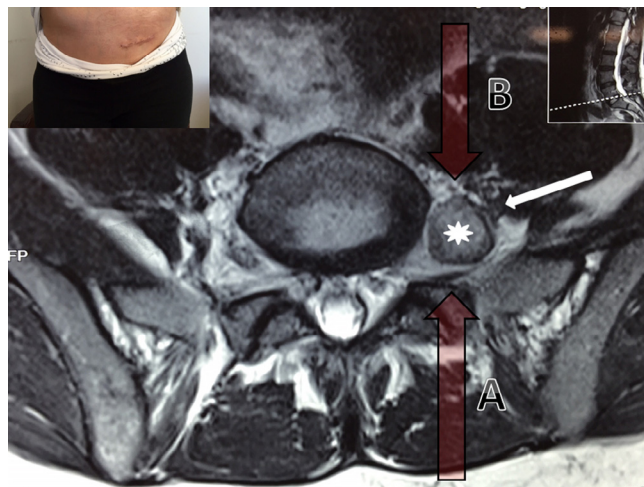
Axial T2WI magnetic resonance imaging (MRI): Foraminial schwannoma (asterisk). L5 nerve pushed laterally by lesion (white arrow). (A) Potential posterior approach with facetectomy to resect lesion. (B) Potential anterior approach to resect lesion. Inset demonstrates location and size of incision for the described approach.
